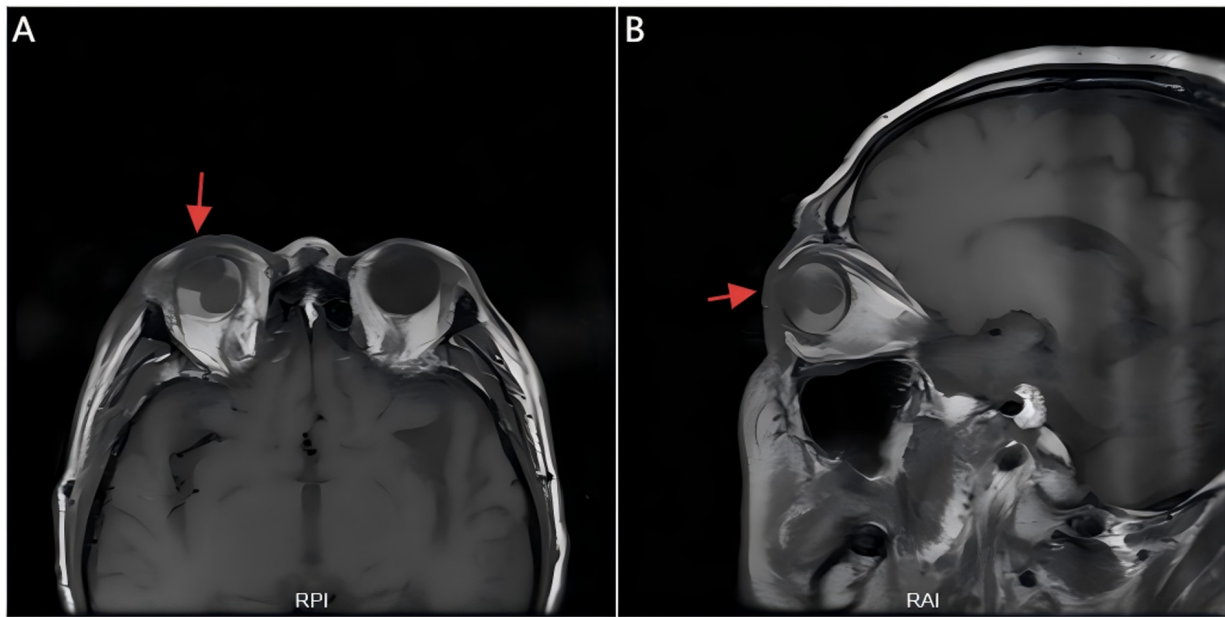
Orbital MRI showing choroidal metastasis in the right eye. (A) Axial view reveals an intraocular mass with associated retinal detachment (red arrow). (B) Sagittal view confirms choroidal thickening and elevation of the retina (red arrow). RAI, right-anterior-inferior; RPI, right-posterior-inferior.
